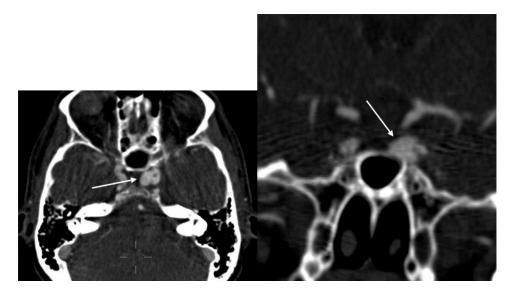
Axial and coronal CTA view showing the cavernous left ICA aneurysm (arrows), which is medially oriented and partially intrasellar.
